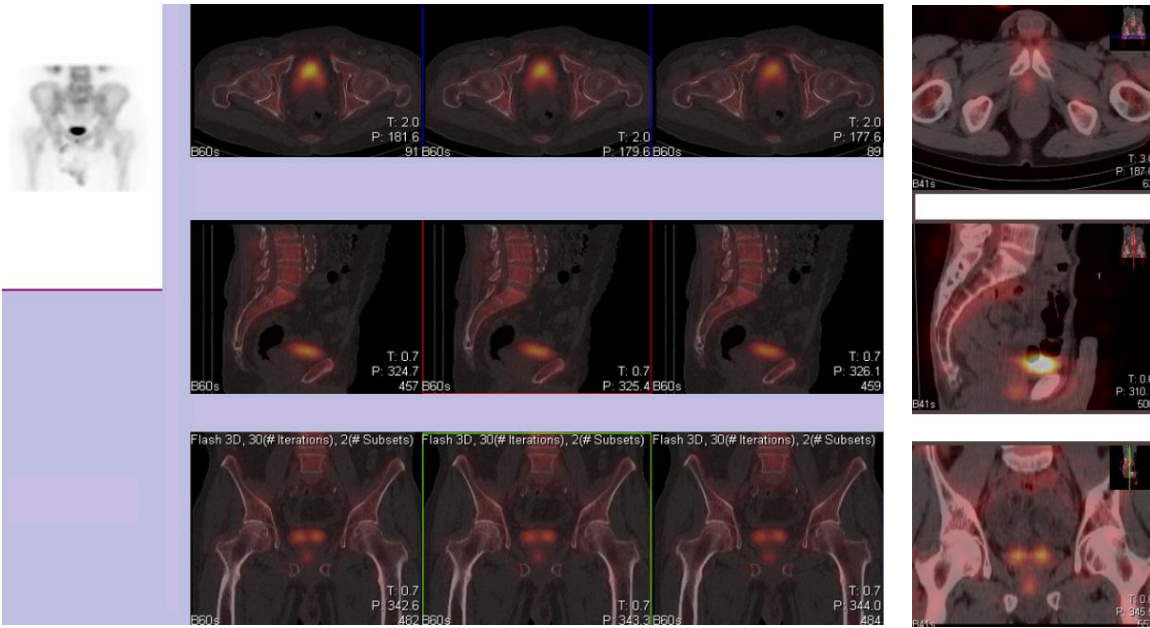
SPECT/low-dose CT imaging of the pelvis. The fused SPECT/CT images demonstrate focal radiotracer uptake localized to the prostate gland. The prostate appears mildly enlarged, but no evidence of calcifications is observed on the CT images
